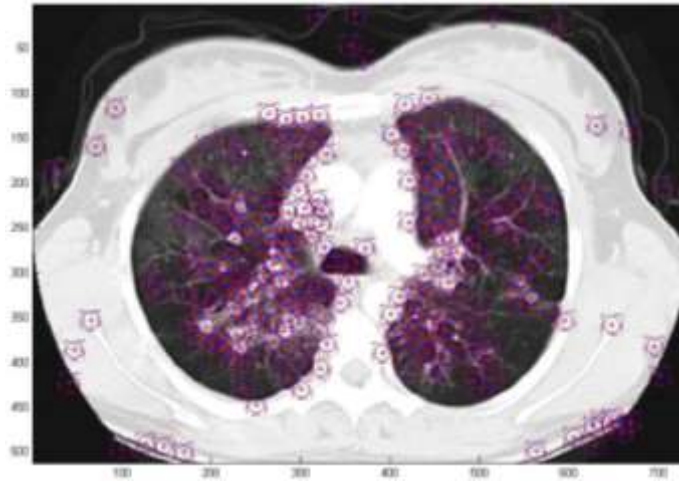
Hough transform applied to the CT image
